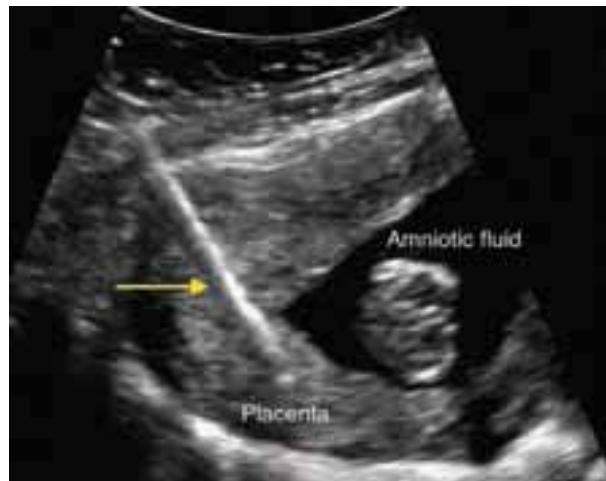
Ultrasound image of chorionic villus sampling. The needle (arrow) is seen in the placenta. (Photo courtesy: Mediscan Systems, Chennai.)
